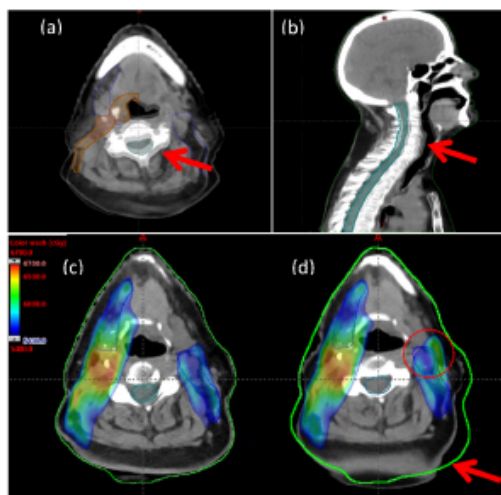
Axial (a) and sagittal (b) views of setup variation in the neck region between planned and actual treatment positions for Patient 4. Blended images of planning CT and vCT shown demonstrating differences in the neck angle as indicated by red arrows. Nominal dose distribution on the planning CT is shown in (c) with CTV 54 contour in blue and the corresponding vCT dose. Green body contour of the planning CT is shown in (c) and (d). Red dotted circle in (d) indicates region of hotspot outside of CTV 54 and cold spot within CTV 54. Red arrow in (d) indicates region with variation in setup position. CTV, clinical target volume; vCT, virtual CT.
